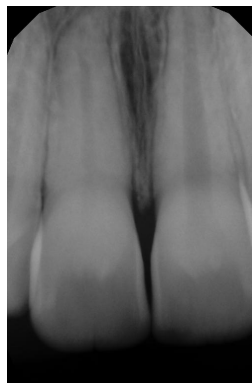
An intraoral periapical X-ray of the upper central incisors three and a half years after injury
